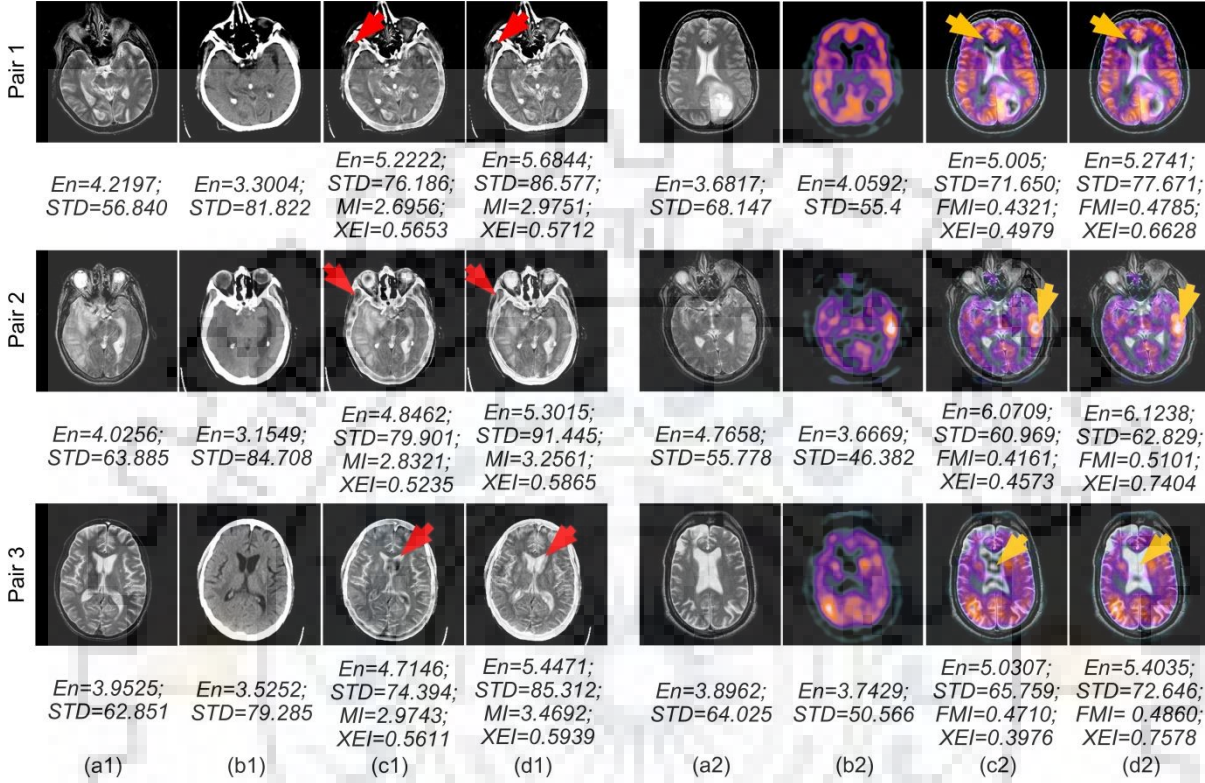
(a1) and (a2) Source MR images (b1) Source CT images (b2) Source SPECT images, fused images based on the proposed method in which dictionary is trained by (c1) and (c2) only natural images (d1) and (d2) medical and outdoor images
